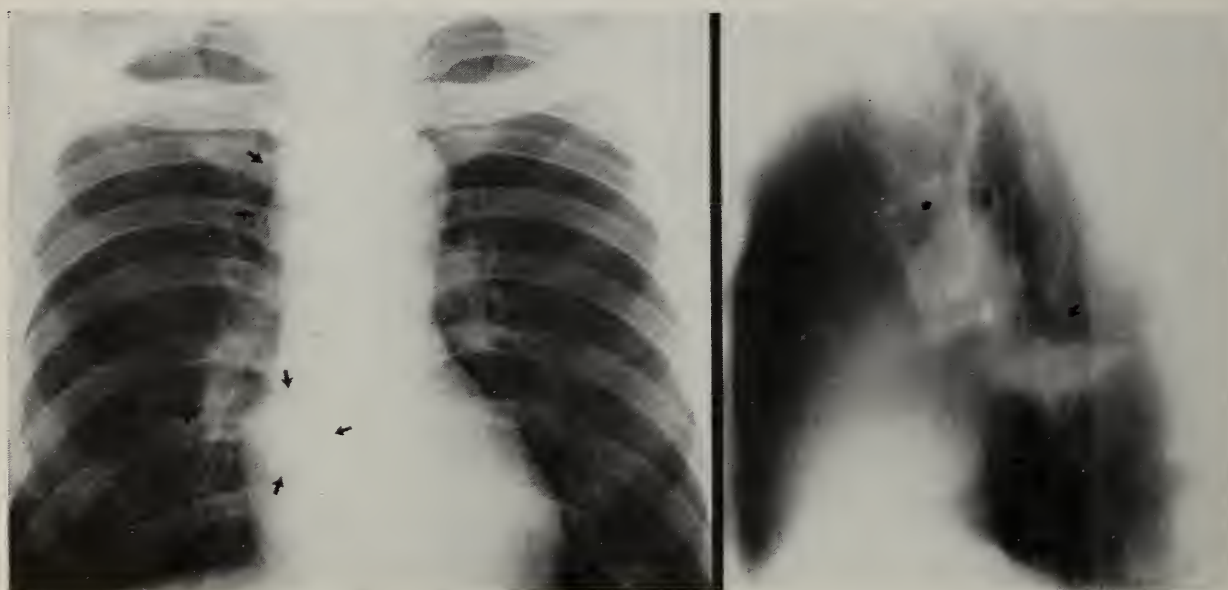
The patient is a 47-year-old Negro man who had right coronary endarterectomy in April 1962. Reevaluation in December 1962 revealed malaise, dry cough, chest discomfort and weight loss over several weeks. Chest x-ray studies showed presence of right paratracheal adenopathy (upper arrows), right hilar adenopathy (middle arrows), and a dense infiltrate in the subsegment of the RLL (lower arrows), which had not been present previously. Lateral tomogram demonstrates the infiltrate in the right lower lobe more clearly. Sputum cultures and bronchoscopy were negative. Coccidioidin skin test was strongly positive (5 cm induration), as was tuberculin skin test. Coccidioidal complement fixation was positive at 1:8 dilution, precipitins at 1:10. The patient had lived in the San Joaquin Valley for three months before admission. Supportive therapy was given.
